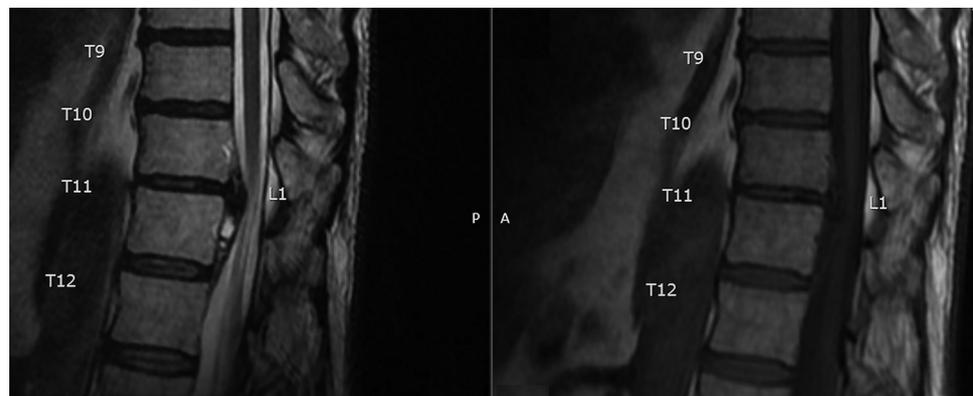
MRI scan of the thoracic spine eliminating suspicion for spinal epidural abscess.
